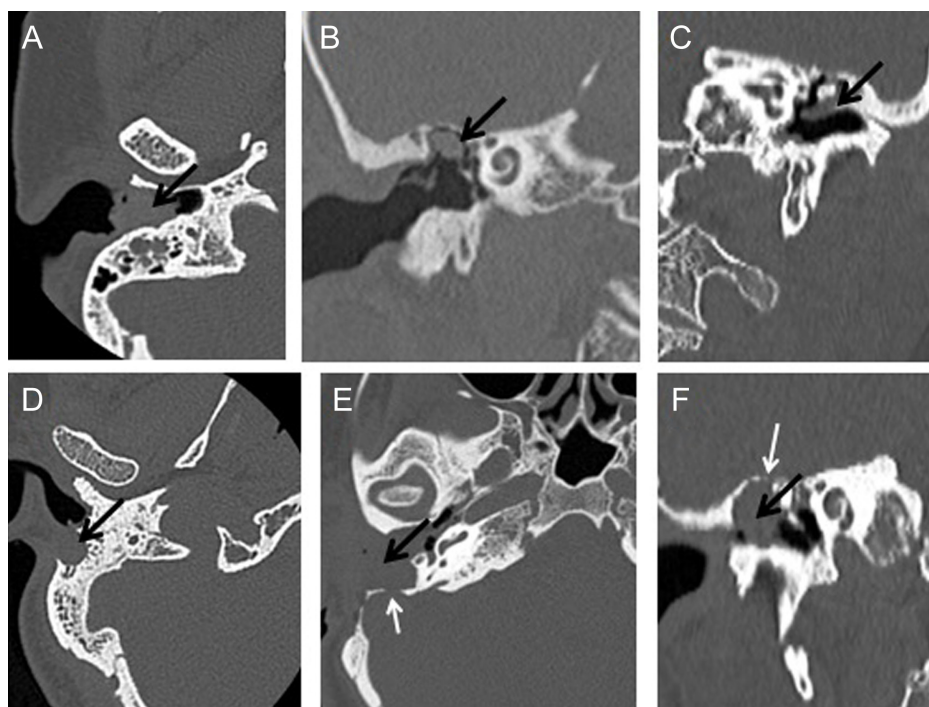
The localization definition examples in temporal bone CT images. (A) Right-sided cholesteatoma in external auditory canal (arrow). (B) Right-sided cholesteatoma in superior attic recess (arrow). (C) Left-sided pars flaccida cholesteatoma (arrow). (D) Right-sided mastoid air cell cholesteatoma with bony erosion (arrow). (E) Right-sided cholesteatoma in mastoidectomy cavity (black arrow) and bony erosion in the occipital bone (white arrow). (F) Right-sided cholesteatoma originating from the lateral epitympanic recess and extending into the external auditory canal (black arrow) and bony destruction in the tegmen tympani (white arrow). CT, computed tomography.
